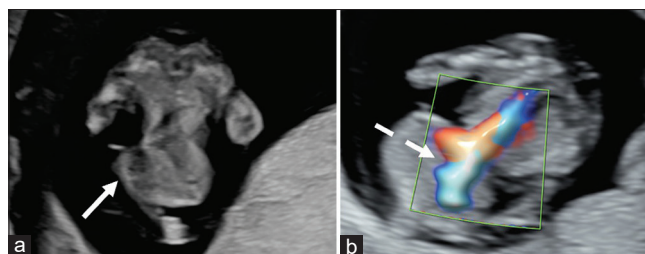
Obstetric ultrasound: transverse section of the midline defect (a, full arrow) and ectopia cordis (b, dashed arrow) without (a) and with (b) color Doppler
